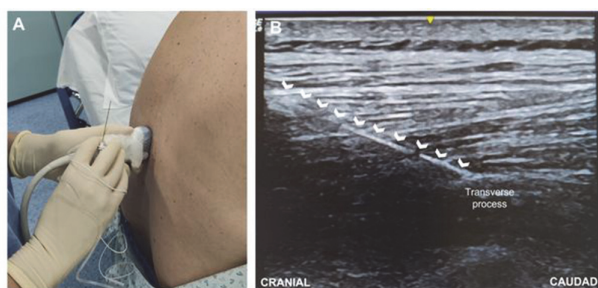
A – Ultrasound transducer position to perform ESPB at T9 level. B – Ultrasound image of thoracic ESPB.
